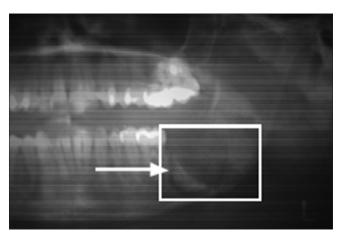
Orthopantomogram showing the remaining portion of the lesion
